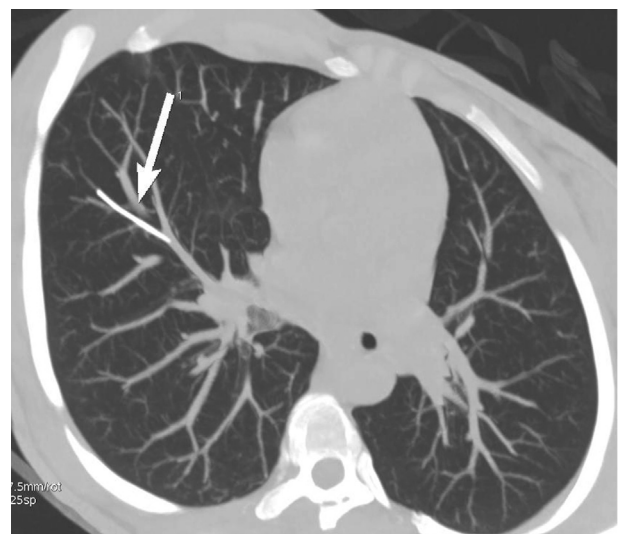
Nexplanon (MSD) (arrow) in subsegmental artery of S8 at computed tomography scan.
